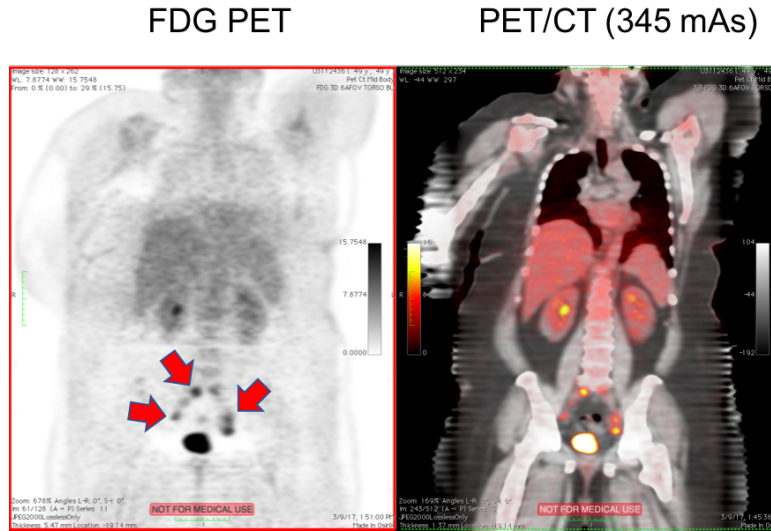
Representative PET and PET/CT images of a suspicious uterine cancer patient (Patient 2)
